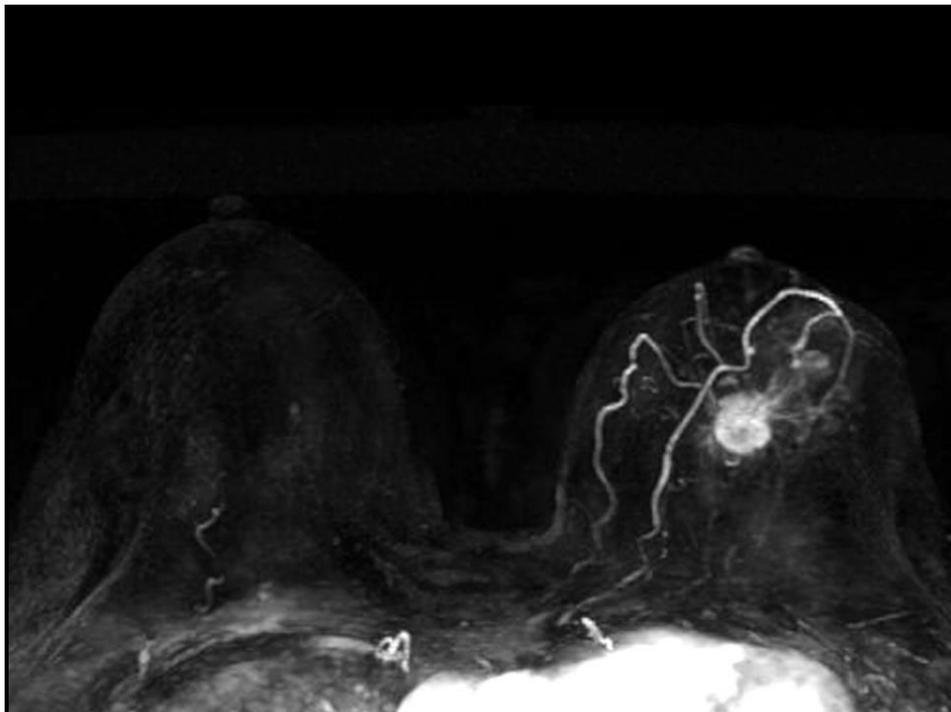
Representative image of UF-DCE MRI (MIP)
